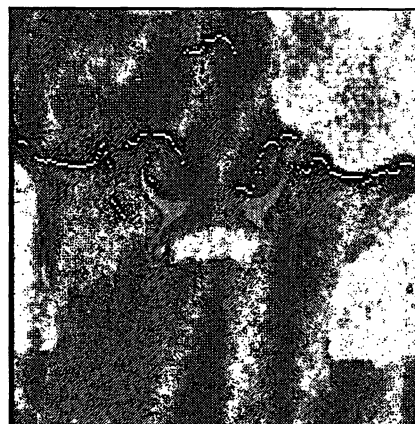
Slice of CT data, the surface elements that are visible for the ultrasound are marked white.
